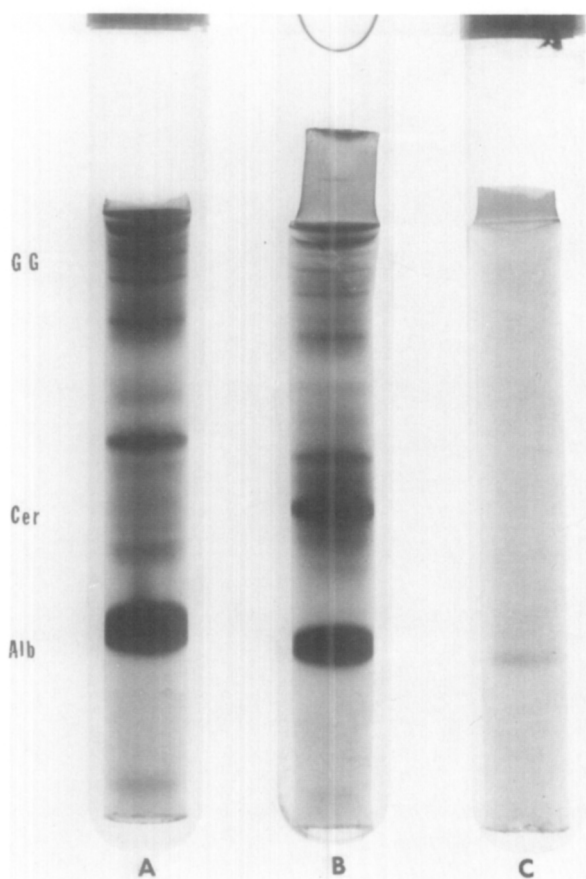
Polyacrylamide-gel electrophoretic patterns from Case 29; radicular cyst with apical region of canal calcified and consequent failure of penetration of cyst lumen from the root canal. *A*, Fingertip plasma. *B*, Periapical plasma. *C*, Root canal fluid. *Alb*, Albumin; *Cer*, ceruloplasmin region; *GG*, gamma globulin region.
